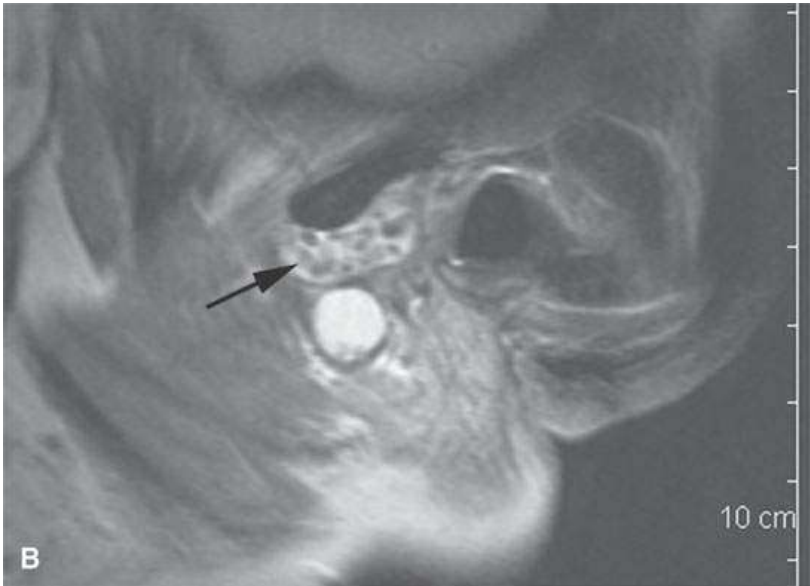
Magnetic resonance imaging of temporomandibular joint osteochondromatosis. The T1-weighted image in (A) shows signal voids in the joint (arrows) and a likely distended joint capsule. The T2-weighted image in (b) shows the distended joint capsule (arrow) and multiple areas of ossific density as voids with the pathologic joint space.
